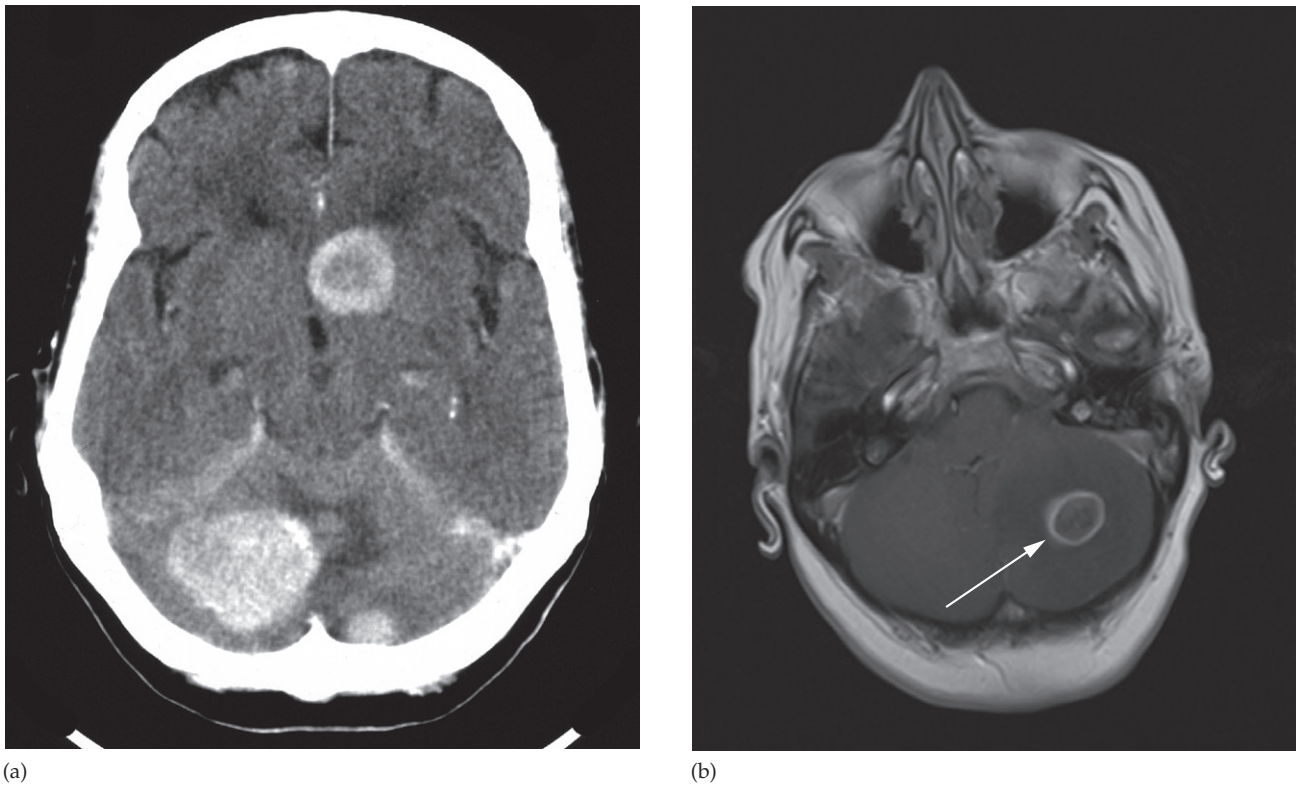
Metastases. (a) Enhanced CT scan showing several metastases as rounded areas of increased density in the cerebral and cerebellar hemispheres. (b) Enhanced T1-weighted MRI scan showing a ring-enhancing cerebellar metastasis (arrow).
